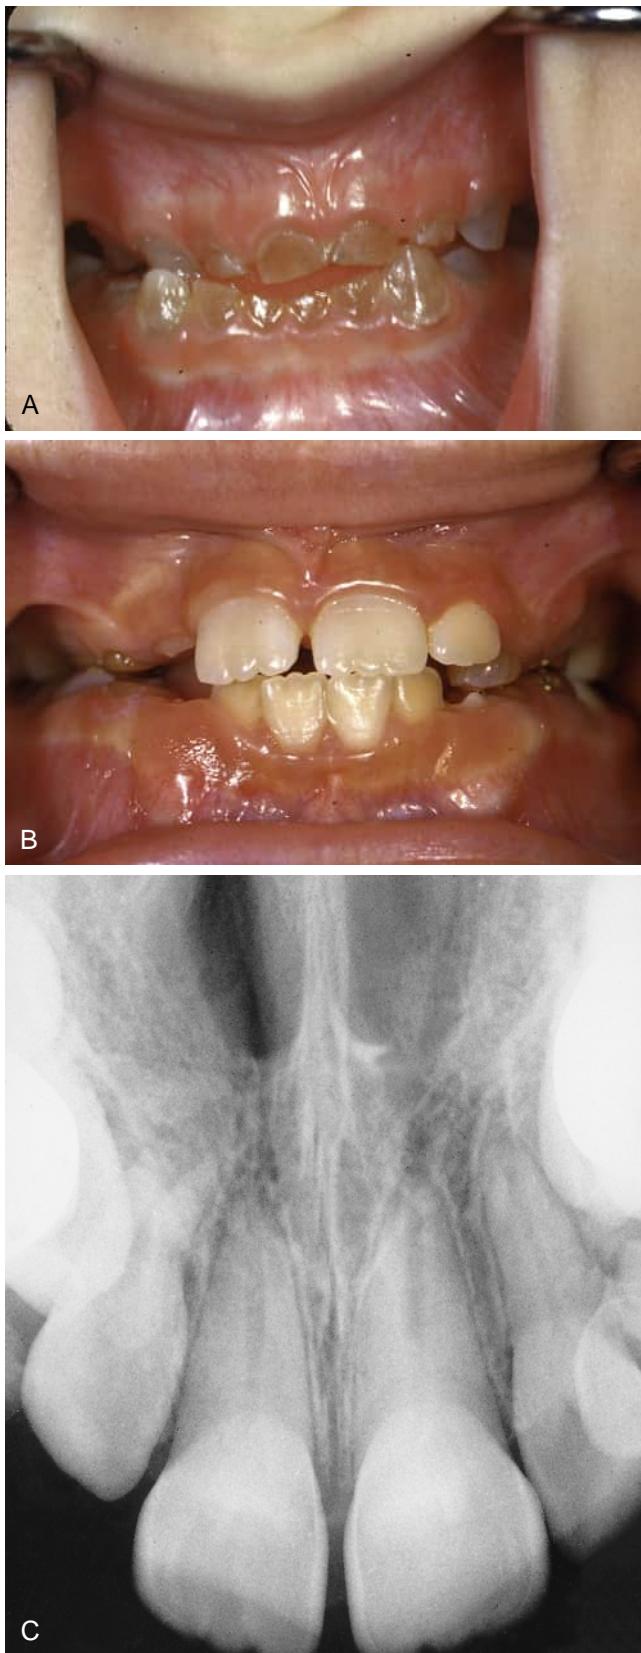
(A) Four-year-old child with dentinogenesis imperfecta. (B) The permanent teeth, in contrast to the primary teeth, are normal in color. (C) The radiograph shows typical dentinogenesis imperfecta.
